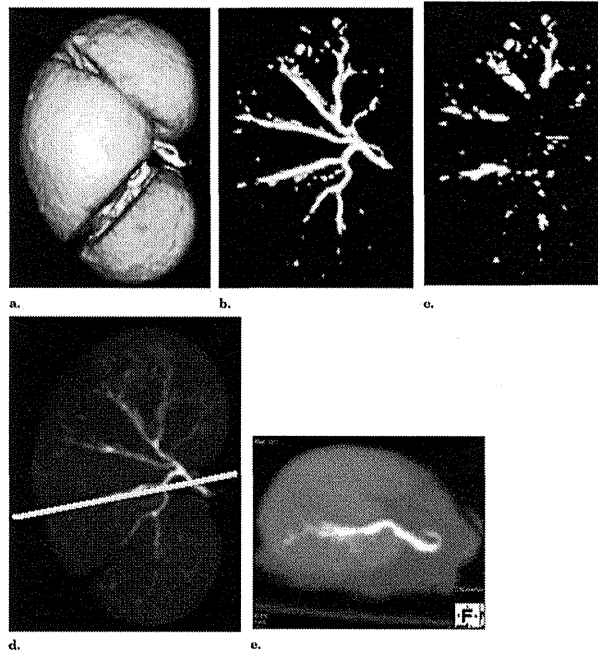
CT volume rendering image and volumetry of the kidney after embolization with NBCA-Lip (1:9). (a) CT volume rendering image of the kidney. (b) CT volume rendering image of the region with a CT value > 500 HU. CT volumetry of this region evaluates the total vascular bed in which the embolic material was distributed. (c) By removing the medullary vessels on source images, volumetry of the vascular bed in which embolization was accomplished only in the cortex was achieved. To consider individual differences in the vascular bed of the kidney, the cortex/total kidney ratio was evaluated. This was considered to be the index of the distal embolization effect. (d) Maximum intensity projection of the kidney. (e) CT axial image of the position of the line on image (d). For pathologic preparation, a region with a high level of NBCA-Lip on CT similar to this was chosen.
